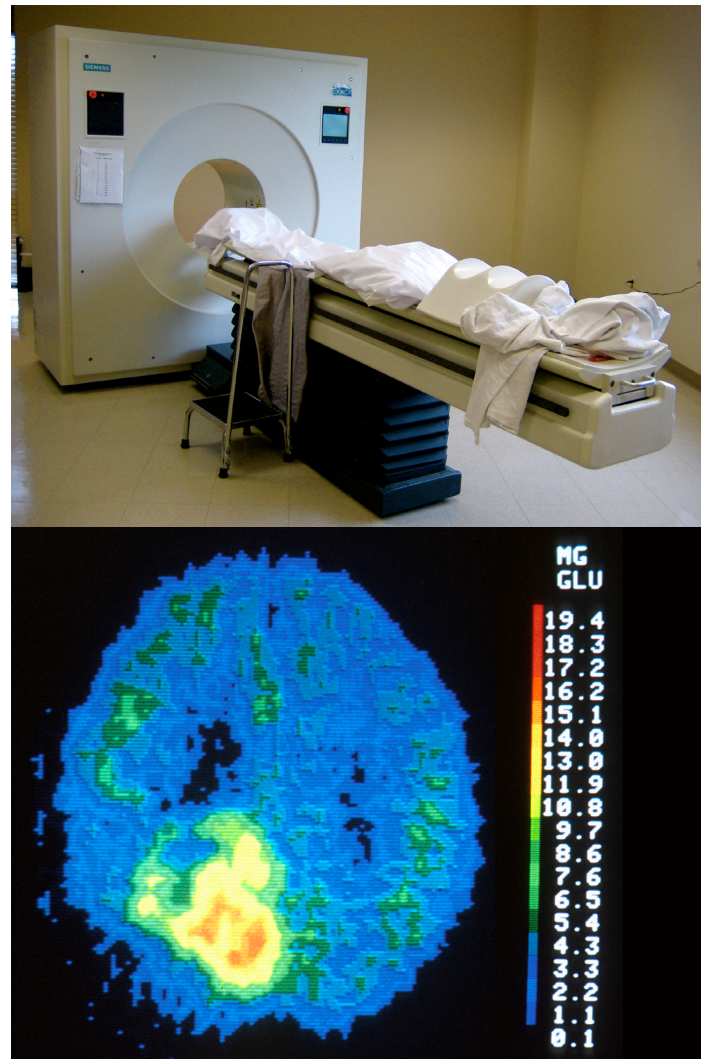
The positron emission tomography (PET) scanner (top) is quiet compared to the CT scan or MRI. It can generate data sets (bottom) that visualize the approximate location of highly-energetically demanding tissue (yellow and orange), such as a brain tumor.
